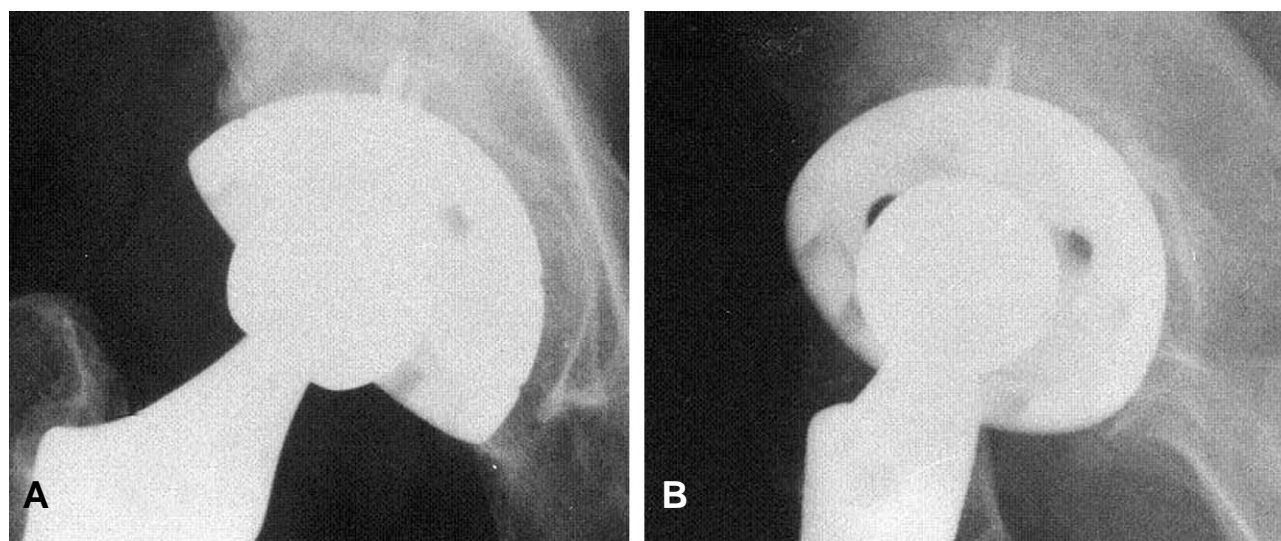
(A) The radiolucent line is not visible on the anteroposterior radiograph. (B) The radiolucent line can be seen easily on oblique view.
